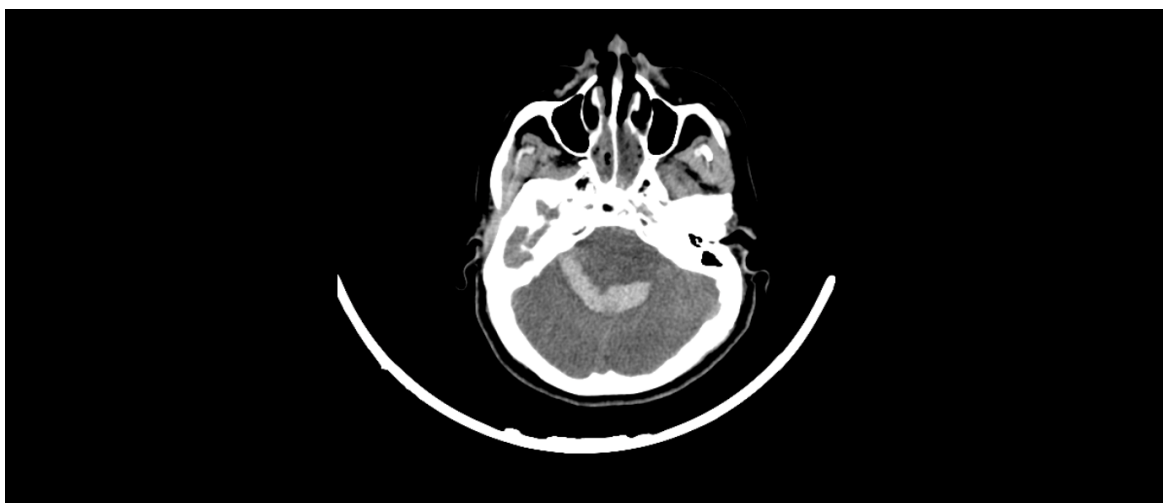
Axial non-contrast brain CT scan reveals SAH in quadrigeminal and ambient cistern and also interpeduncular cistern in anterior aspect of the midbrain. Also, evidence of extension of the hemorrhage into the posterior flax cerebri is seen. Intraparenchymal hemorrhage is seen in both cerebral hemisphere and vermis
